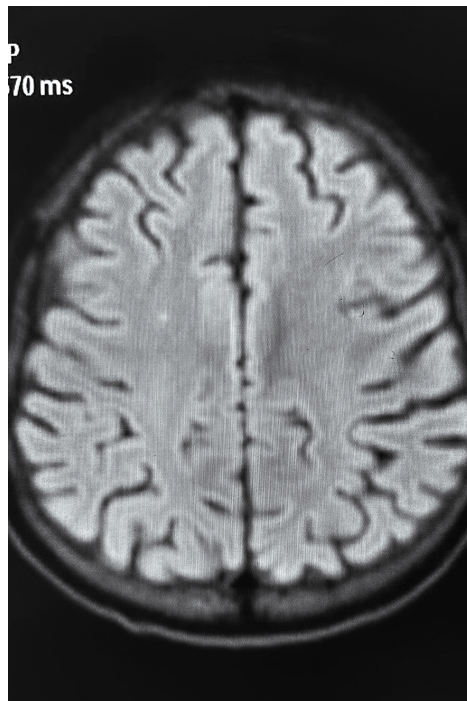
DWI magnetic resonance of the brain shows an acute infarct in the right frontal lobe of the cerebrum.
